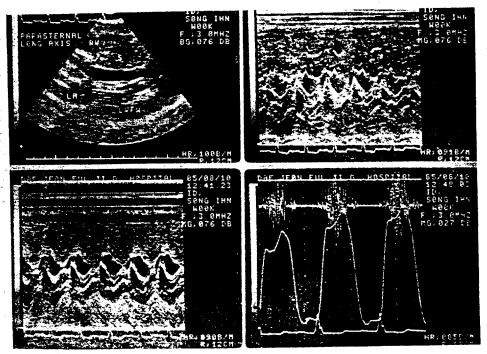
Pre-operative echocardiography. LVOFT narrowing was seen and measured only 0.8cm in diameter. M-mode showed SAM-like echogenic density.
